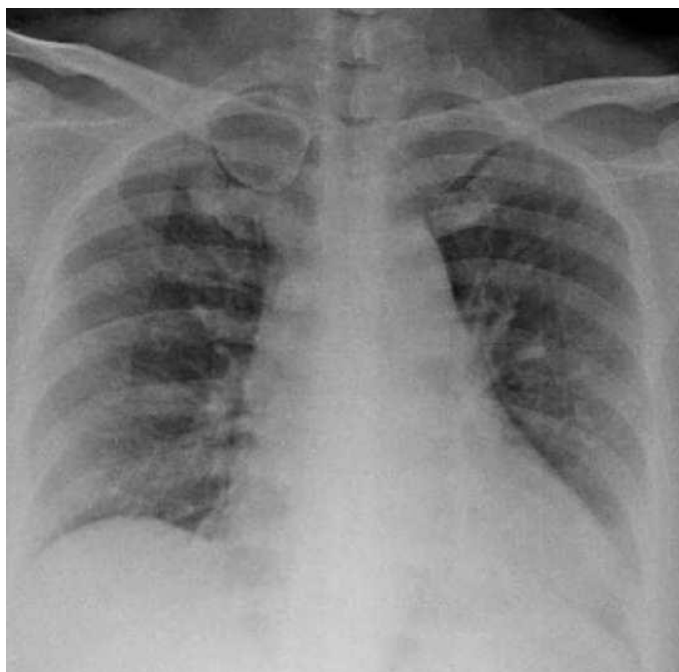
Chest X-ray image of a sick person because of COVID-19 shown in Figure 1d.
